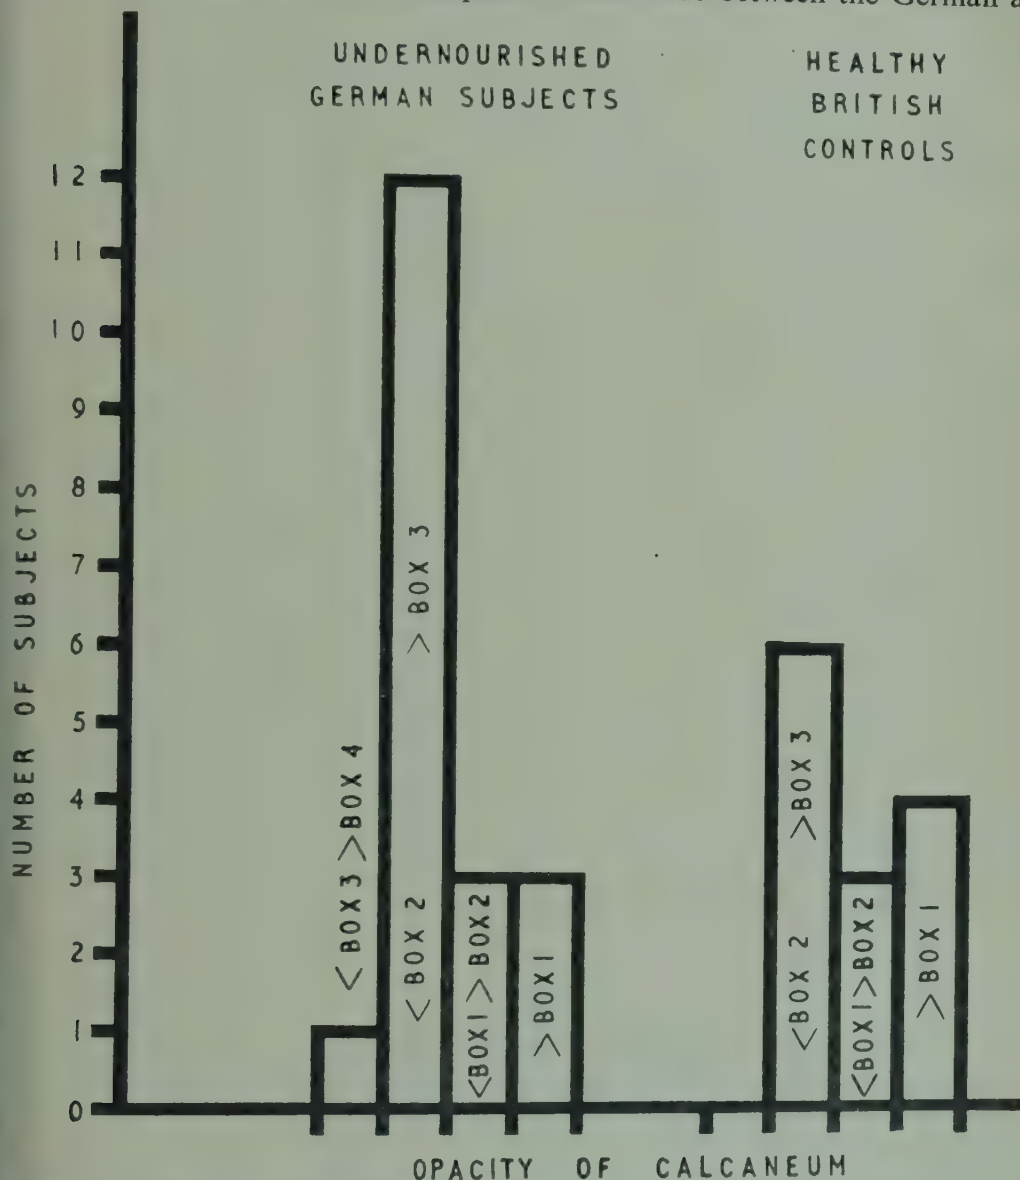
The frequency distribution of the radiographic opacity of the calcanei in 19 undernourished German men and 13 healthy British controls.
